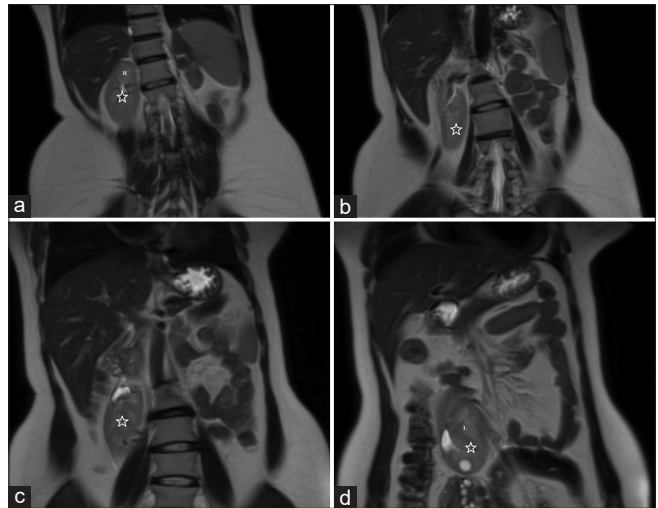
Magnetic resonance imaging of the abdomen in coronal plane showing cross fused renal ectopia (star) in the form of fusion of upper pole of left kidney with the lower pole of right kidney. R: right kidney, L: left kidney
